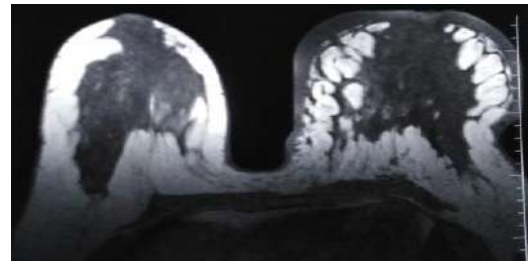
Axial section of T1W MRI breast showing enlarge left breast with diffuse edematous changes, skin thickening and ill defined hypointense lesions in centre of left breast
